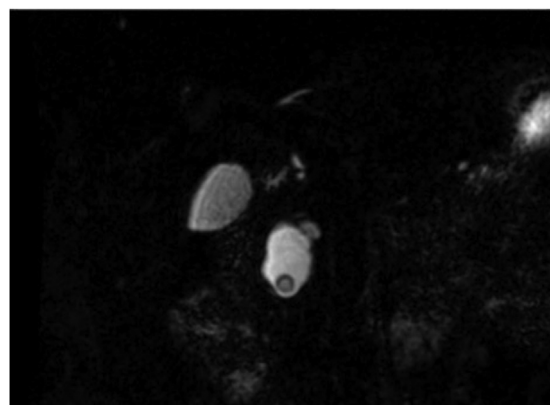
Magnetic resonance imaging demonstrating intracystic nodule.
